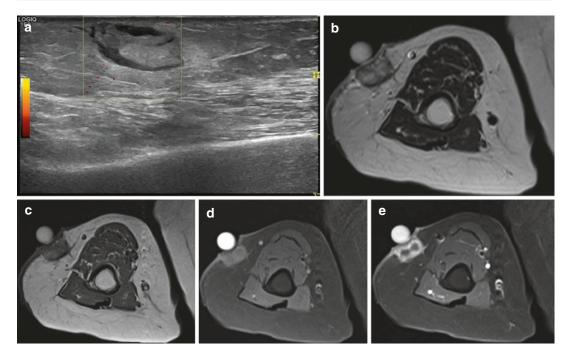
An 80-year-old female patient, presenting with a painless mass at the lateral aspect of the right upper arm, with an area of fat necrosis ("steatonecrosis") at the subcutaneous tissue. US and MRI show characteristics of fatty tissue. (a) Oval area superficial at the subcutaneous tissue with distortion of the subcutaneous fat surrounded with hyporeflective margin, diameter 2 cm, avascular on CDUS. (b) Axial TSE T2-WI. Nonhomogeneous lesion
